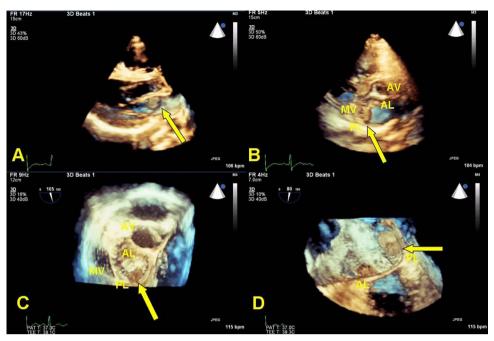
(A) Real-time three-dimensional transesophageal echocardiography (3D-RT-TEE) with mitral valve vegetation (arrow). (B) 3D-RT TTE from left atrial perspective with mitral valve vegetation (arrow) (C and D) 3D-RT-TEE from left atrial perspective with vegetation (2.5×2.7 cm) involving posterior annulus of the mitral valve (arrow).
